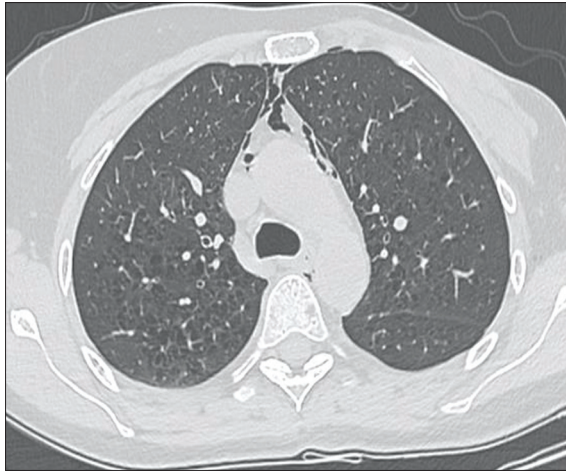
Follow-up CT a week later at mediastinal level shows partial resolution of pneumomediastinum
